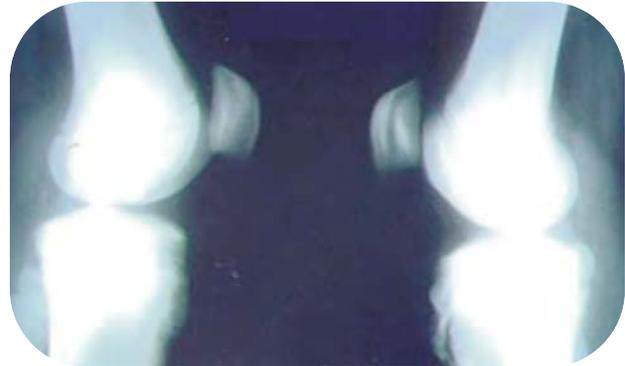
22 months follow up radiograph of both knees showing well united tuberosities
